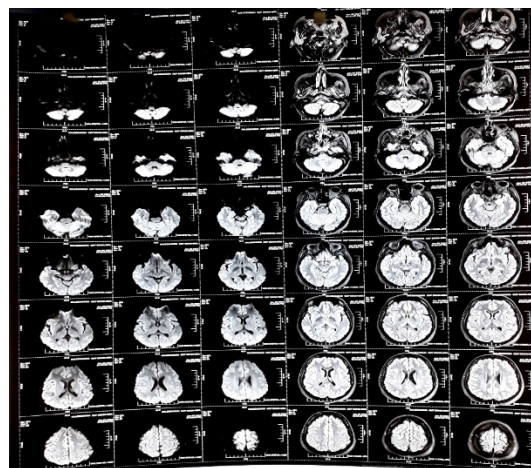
showing MRI brain having diffuse and multiple punctate T2 FLAIR hyperintensities in bilateral brain parenchyma.
